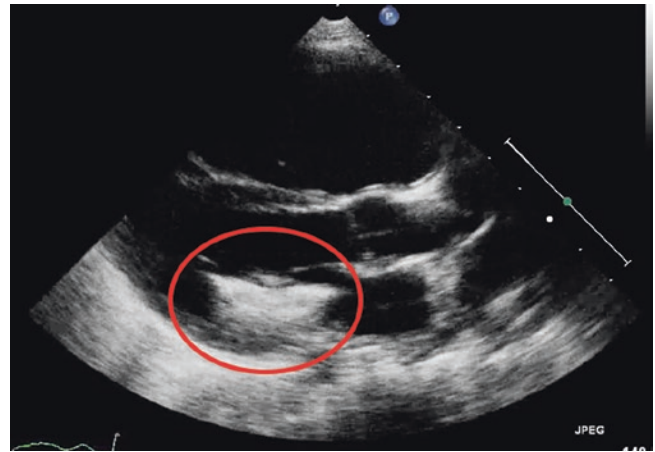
TTE, parasternal long axis. Embolised Amplatzer device (circled) in the LA/LV
